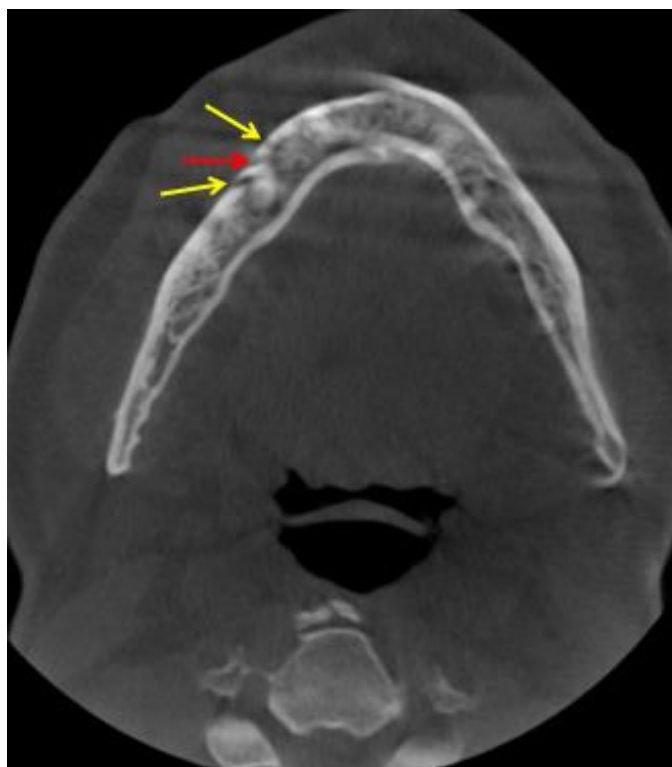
Axial section of CBCT scan showing mental foramen (red) with 2 accessory mental foramina (yellow).
